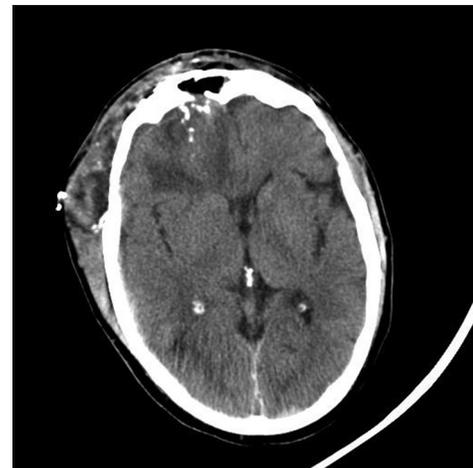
Axial computed tomographic image, postoperative day three after intracranial pressure monitor had been removed
